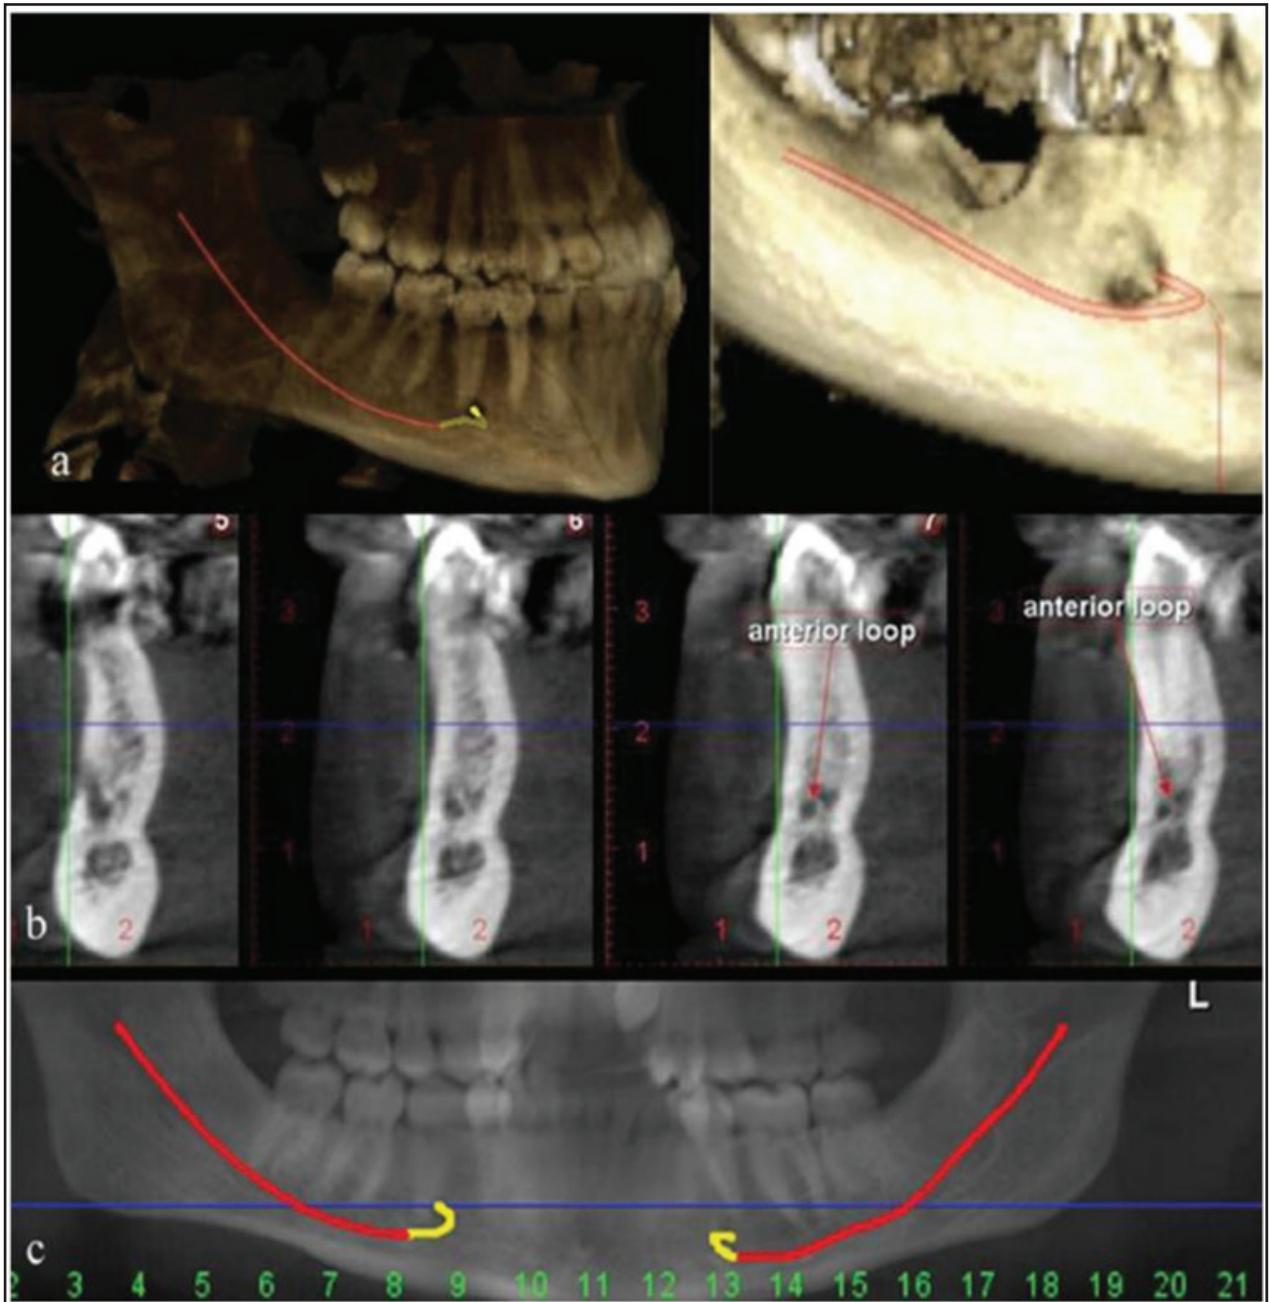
CBCT showing multi-planar slices of a area of interest
